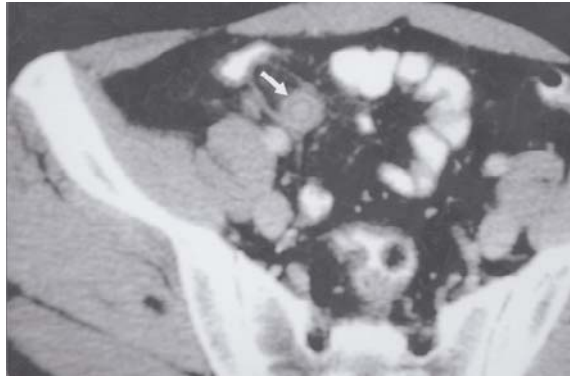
Enhanced axial CT image shows a dilated 1.2cm appendix with periappendiceal stranding (arrow).
